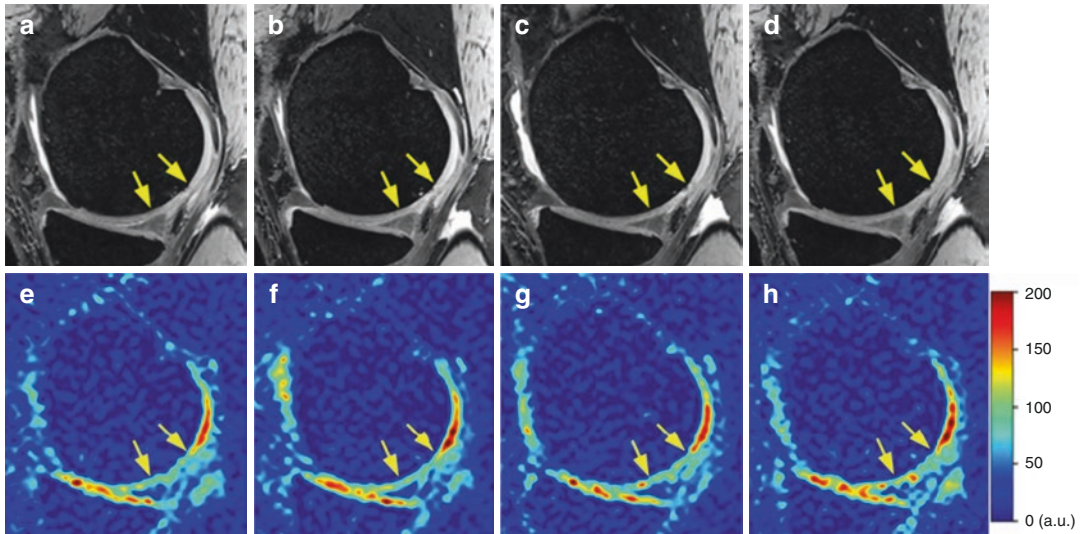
Follow-up sagittal MRI scans of a 26-year-old patient with a low-grade chondral lesion (between yellow arrows) in the weight-bearing region of the medial femoral condyle. Morphological DESS images (a–d) and corresponding color-coded ^{23}Na images corrected for coil sensitivity (e–h) acquired at baseline (a, e), 1-week (b, f), 3-month (c, g), and 6-month (d, h) follow-up visits at
